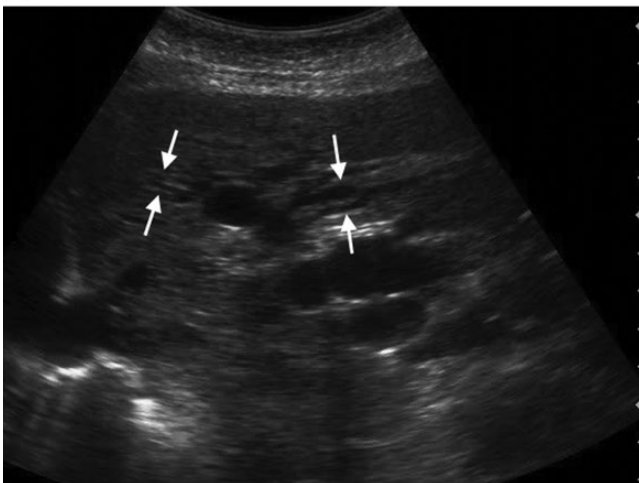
(a–c) Images of common bile duct (CBD) obstruction and intrahepatic cholestasis (IHC) due to pancreatic head neoplasm. (a) A transverse view demonstrates the porta hepatis with a CBD containing sludge and with a diameter >2 cm (compare to the 1-cm depth markers). The sludge compresses both the portal vein and inferior vena cava (arrowhead; VB: vertebral body). (see Video 14.3, from which this image was taken). (b) and (c) show images of severe IHC with colour-flow Doppler in (a) confirming that the dilated vessels are not vascular. Centrally, this is sometimes called the ‘too many tubes sign’. (c) More peripherally, the ‘parallel tracks’ and ‘shotgun’ signs are seen (between the arrowheads and arrows). Images © A.J. Dean.
